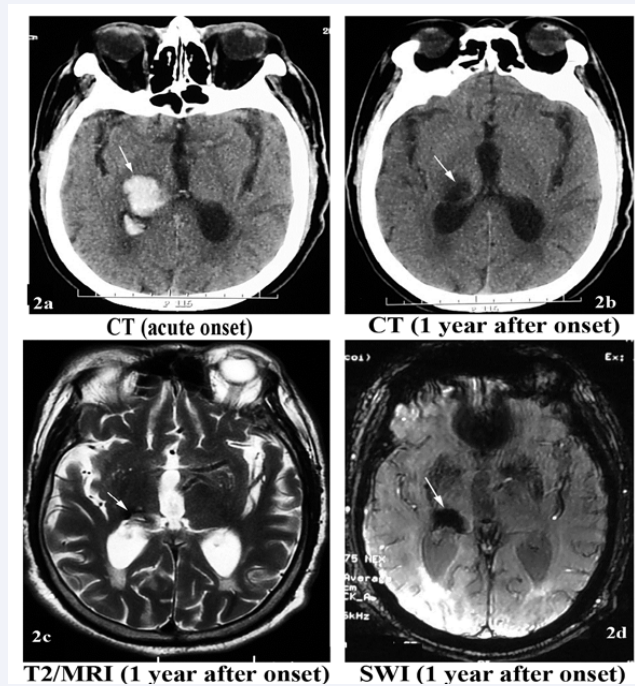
Skull image of case 2; 2a was CT scan on acute onset of thalamic hemorrhage; 2b was CT reexamination of the patient at 1 year after the onset of ICH, 2c and 2d were T2WI and SWI respectively of the case at 1 year after ICH; the lesion was hypointense on T2WI and SWI.
